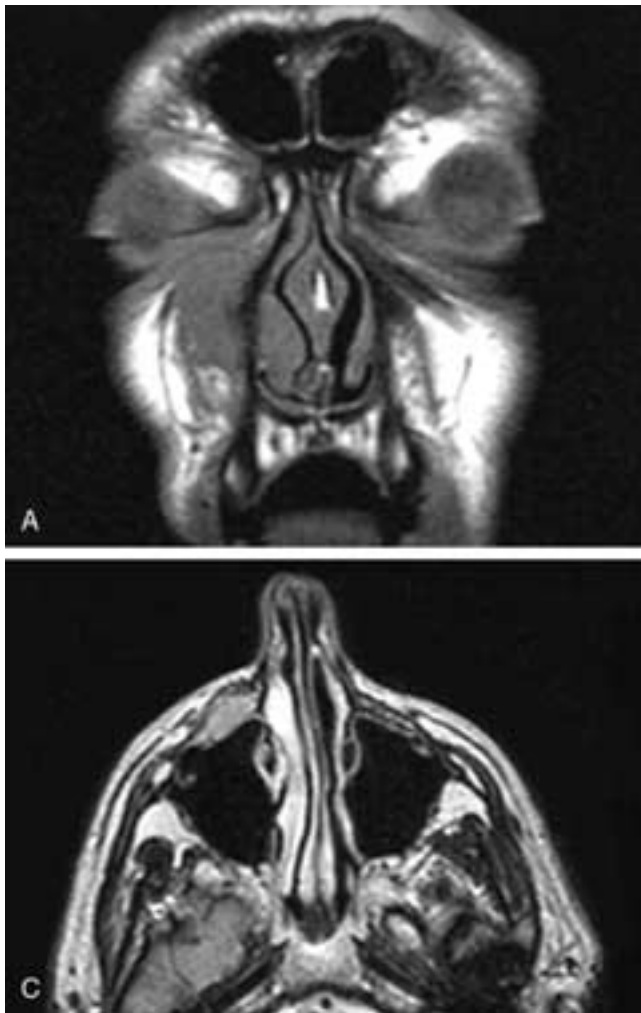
Coronal (A) and axial (B) T1-weighted and axial T2-weighted (C) MR images show a soft-tissue mass in the medial right cheek lying against the anterior antral wall (*arrow*). There may be thinning of the wall immediately adjacent to the mass. The mass has a low to intermediate T1-weighted signal intensity and a higher intermediate T2-weighted signal intensity. This patient had a large cell lymphoma.
